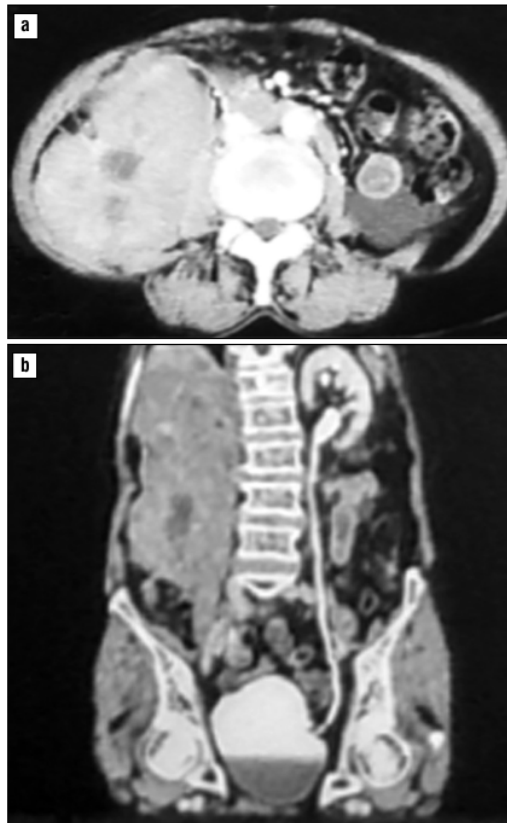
Urography CT scan: right renal mass suggestive of renal cell carcinoma (a) axial view; (b) sagittal view)
